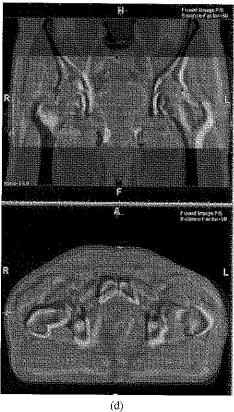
(Cont.) (c) An alternative split screen representation of fusion between CT and MRI data sets. (d) Areas of mismatch between two CT data sets displayed as image enhancement. (Courtesy of OSL and Medcom).
